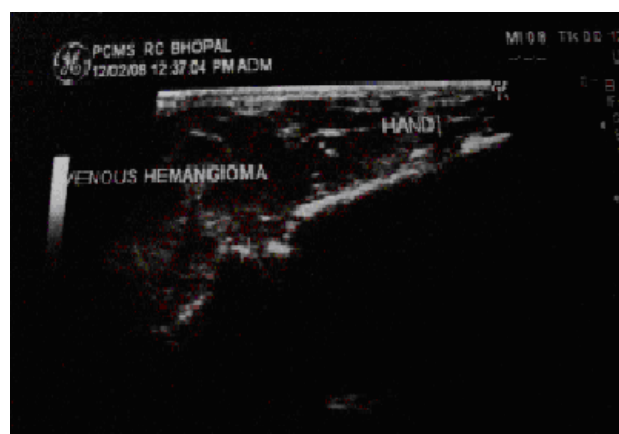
Sonography of dorsal aspect of hand reveal irregular anechoic spaces.
